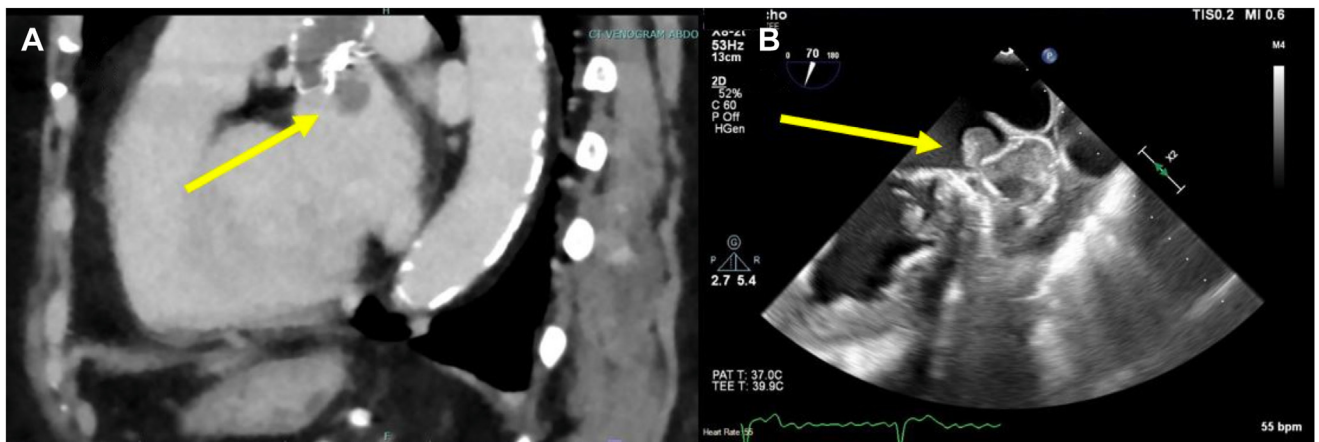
A: Computed tomography venogram sagittal view reveals a 1.1 × 1.3 cm intraluminal filling defect (yellow arrow) extending from the Watchman into the left atrium. B: Transesophageal echocardiogram shows a 1 × 1.3 × 1.5 cm thrombus (yellow arrow) overlying the Watchman device and protruding into the left atrial cavity.
